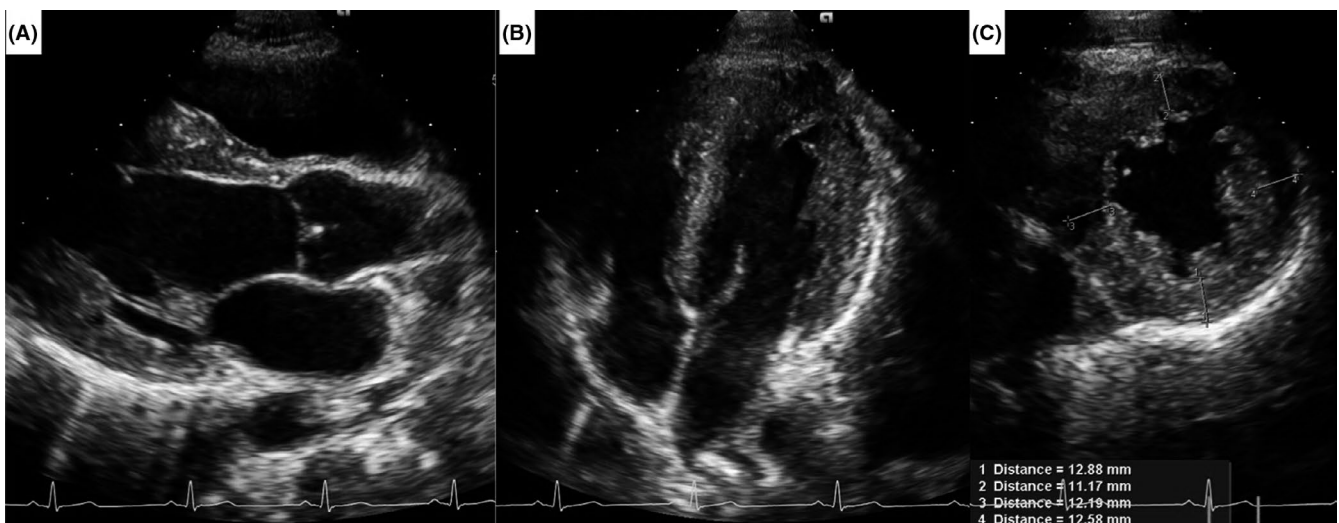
Ultrasound echocardiogram demonstrated the presence of slight left ventricular hypertrophy, and preserved left ventricular ejection fraction. (Intraventricular septum = 12 mm, Posterior wall thickness = 12 mm Left ventricular ejection fraction = 68% (Simpson methods)) No significant valvular disease was observed. (A) Parasternal long-axis view; (B) Apical 4-chamber view; (C) Parasternal short-axis view
